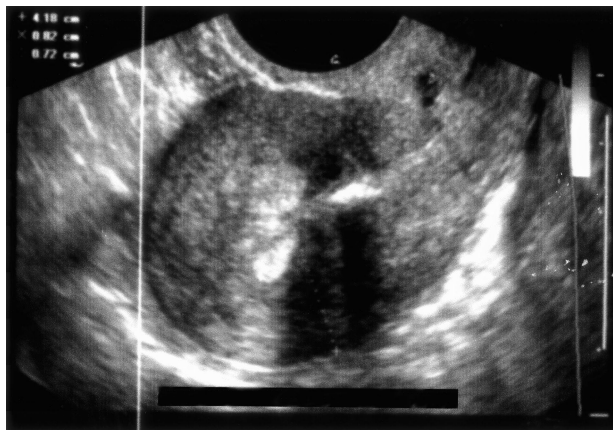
Transvaginal sonography revealed an intrauterine hyperechoic finding in the mid-fundal region (3 years after endometrial ablation).
